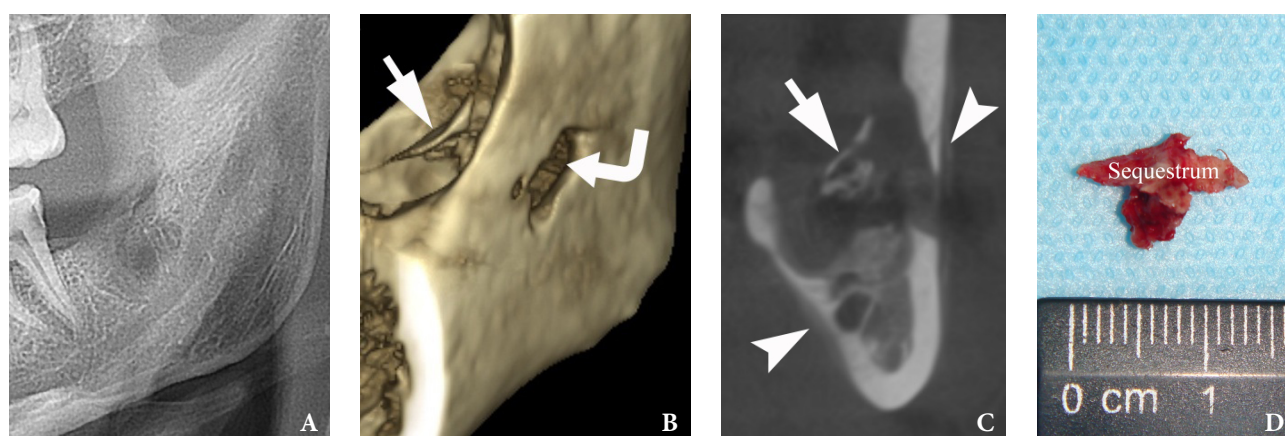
(A) Panoramic radiography at the initial hospital visit (day 28 after tooth extraction). (B) Three-dimensional and (C) coronal CBCT scans on day 51 after extraction. *Arrow*, sequestrum; *curved arrow*, cortical bone defect; *arrowheads*, thin periosteal reaction. (D) Removed mandibular sequestrum on day 62 after tooth extraction.
